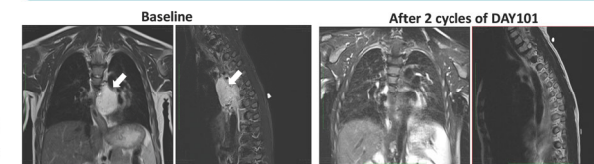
Magnetic resonance imaging (MRI) revealed a mediastinal mass extending circumferentially around the aorta and impressing on the left atrium and pulmonary veins as indicated by white arrows in AP and lateral views. Following 2 cycles of treatment with DAY101, MRI scans revealed only a trace of non-enhancing soft tissue surrounding the descending thoracic aorta.
